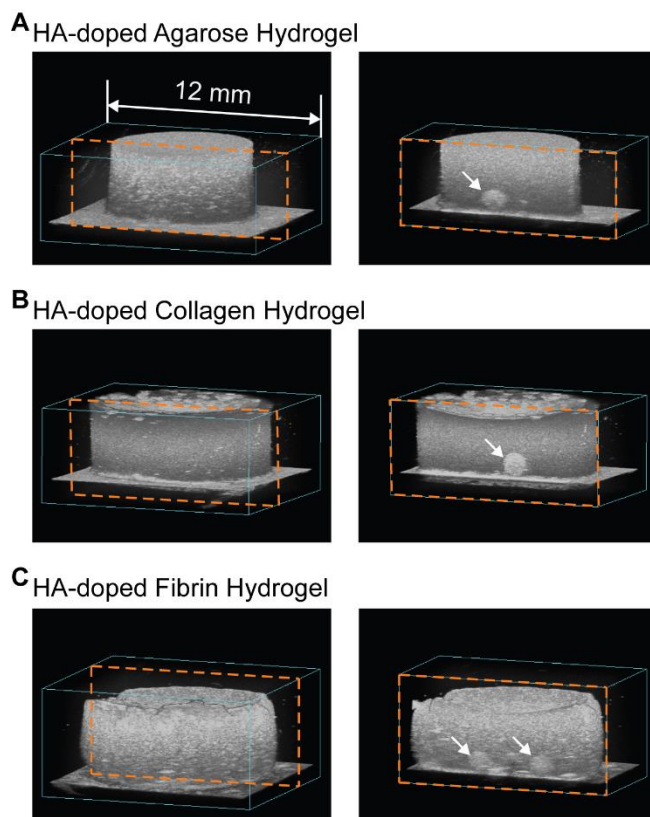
3D rendered ultrasound images of HA-doped (A) agarose, (B) collagen and (C) fibrin hydrogels containing HA-doped agarose bead (white arrows). Left column shows the entire construct. Right column shows a cross-section containing the HA-doped agarose bead.
